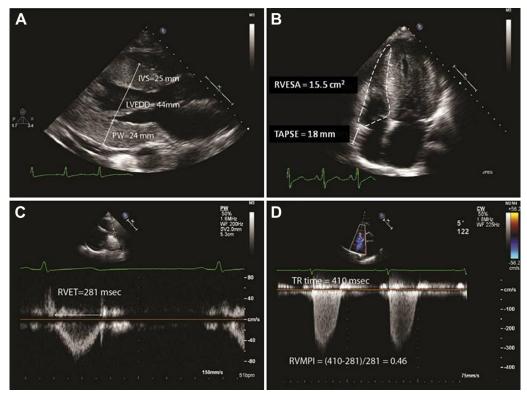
Echocardiographic evaluation. (A) Parasternal long-axis view and 2-dimensional measurement of LV end-diastolic diameter and walls. (B) Apical 4-chamber view and assessment of RV end-systolic area (RVESA) and TAPSE. (C) Doppler analysis of flow at the RV outflow tract with assessment of RV ejection time (RVET). (D) Continuous wave Doppler analysis of tricuspid regurgitation (TR) time and RVMPI.
